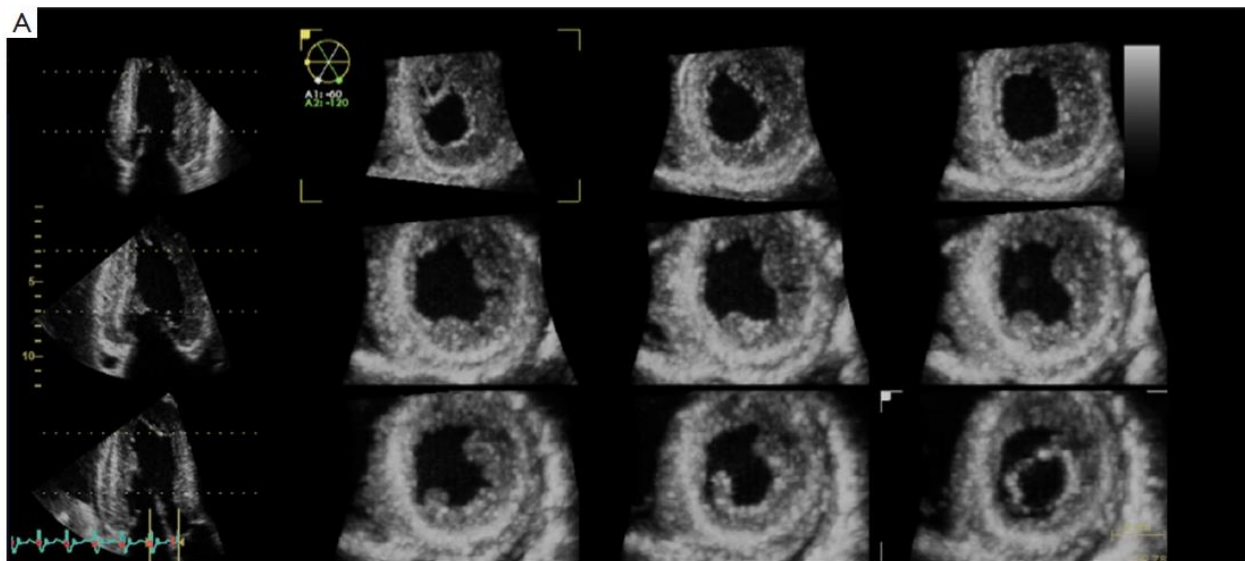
3D image acquisition with the transducer on apex showing simultaneous acquisition of apical four, two and three chamber views and nine cuts of parasternal short axis view (10).
